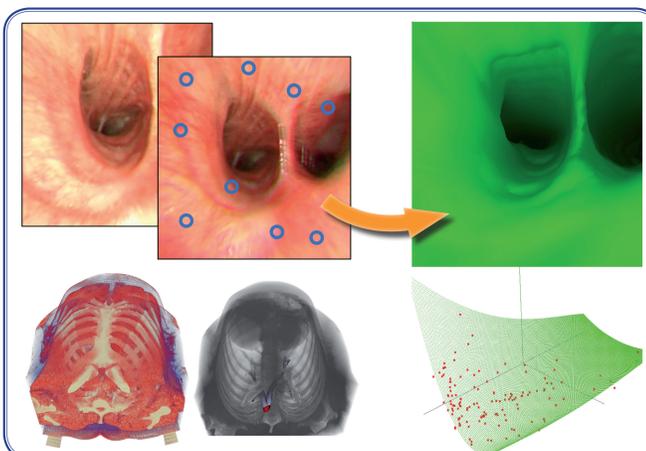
Intra-operative video (top-left) and pre-operative CT (bottom-left) allows modelling organ appearance in real-time. The video is analysed to estimate the tissue's BRDF (right). This becomes a powerful tool for pre-operative training and rehearsal.
